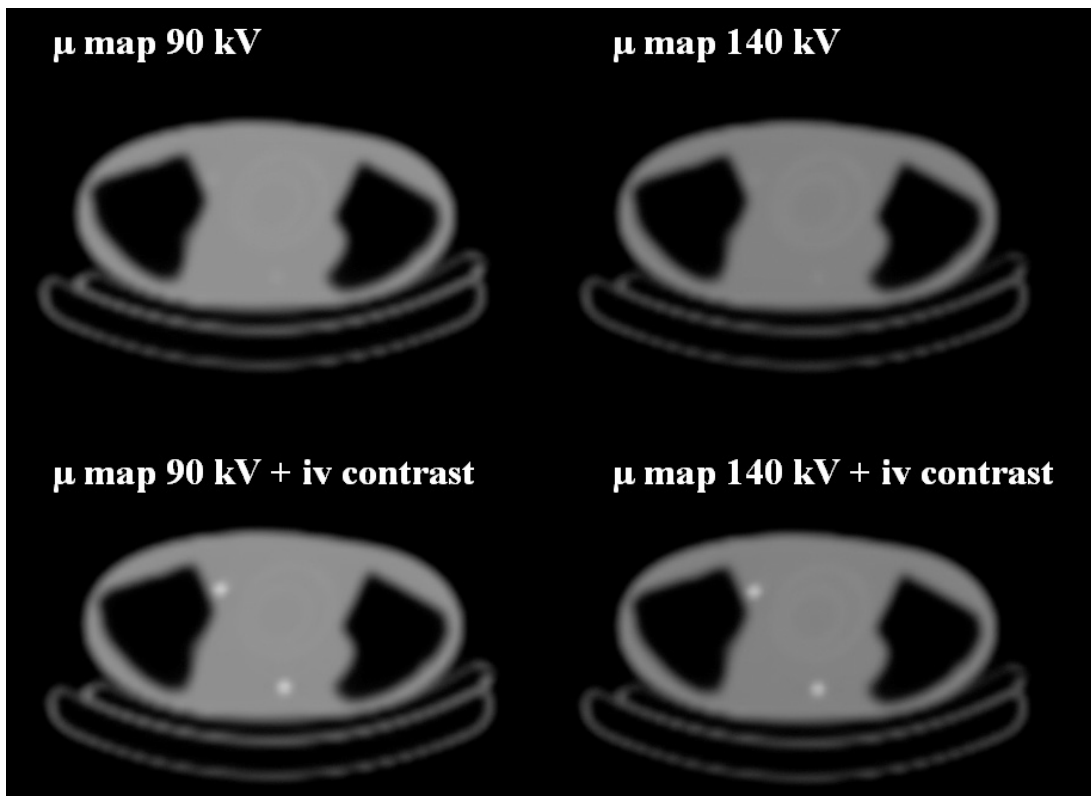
The generated attenuation maps from two different CT kV values each with and without contrast. The extent of the area of increased attenuation is larger than the tube due to the applied smoothing. No streak artefacts are visible.
